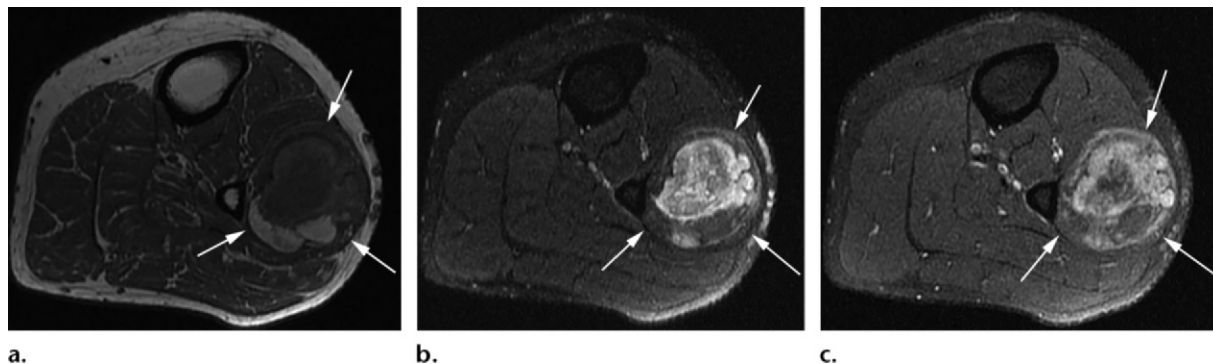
Chondroid lipoma in a 21-year-old man with a slowly enlarging left leg mass. (a) Axial T1-weighted MR image shows a heterogeneous mass (arrows) within the peroneal compartment of the left leg. The majority of the mass is hypointense with a smaller hyperintense portion, suggesting intralesional fat. (b) Axial fat-saturated T2-weighted MR image shows lobulated hyperintense signal (arrows) reflective of chondroid or myxoid matrix. Loss of signal intensity in the posterior portion of the mass confirms the presence of intralesional fat. (c) Axial postcontrast fat-saturated T1-weighted MR image shows heterogeneous enhancement of the mass (arrows). Surgical excision and pathologic evaluation confirmed chondroid lipoma.
